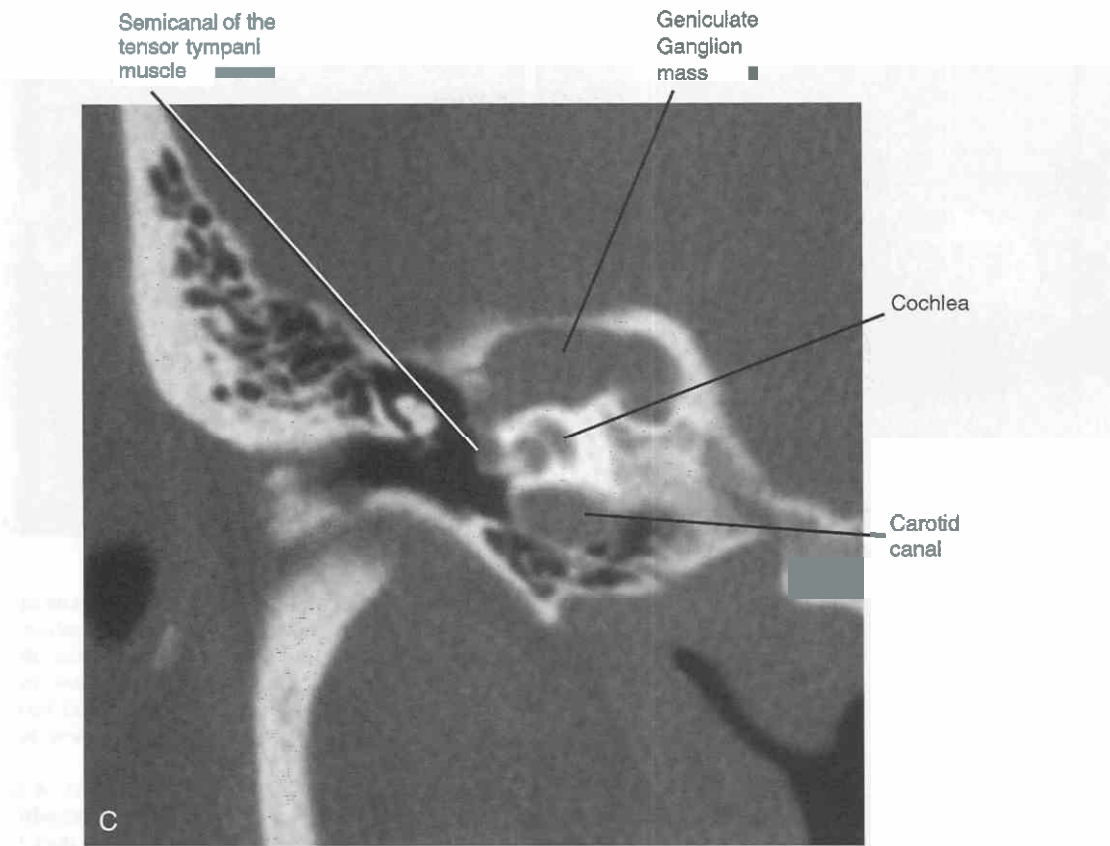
Continued C*, Coronal CT image through the geniculate ganglion region. Note the massive enlargement of the canal superior and medial to the cochlea and carotid canal. The bony canal is smoothly enlarged, a common finding with facial schwannomas and acoustic schwannomas. The location of the bony expansion is centered anteriorly and superiorly in the IAC and along the facial nerve canal.
